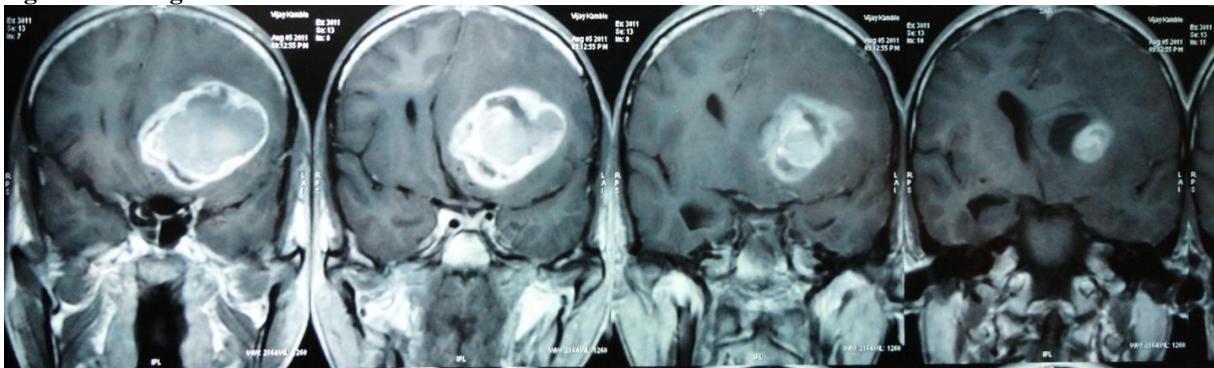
Coronal contrast enhanced MRI image showing a 7.3x5.2x5.4 cm large lobulated hypointense mass with hyperintense calcified component on T1 weighted images.
